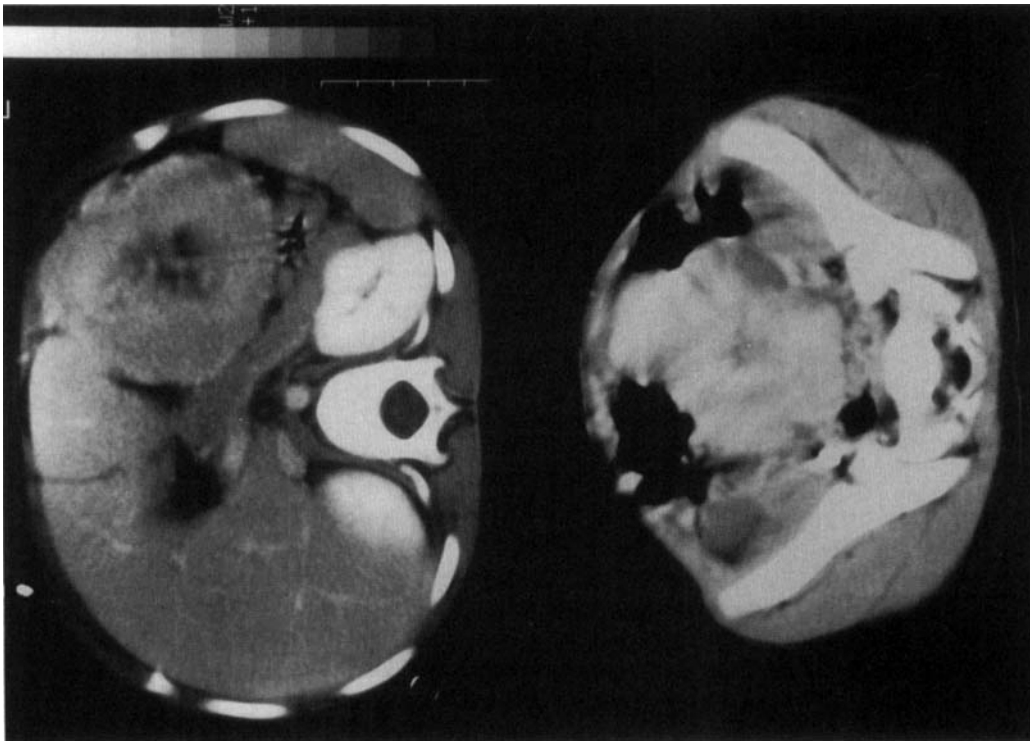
Left: Upper abdominal CT, that shows a solid intraperitoneal mass, with a low density central part, anterior to the tail of the pancreas. Right: solid irregular mass in the pelvis of the same patient.
